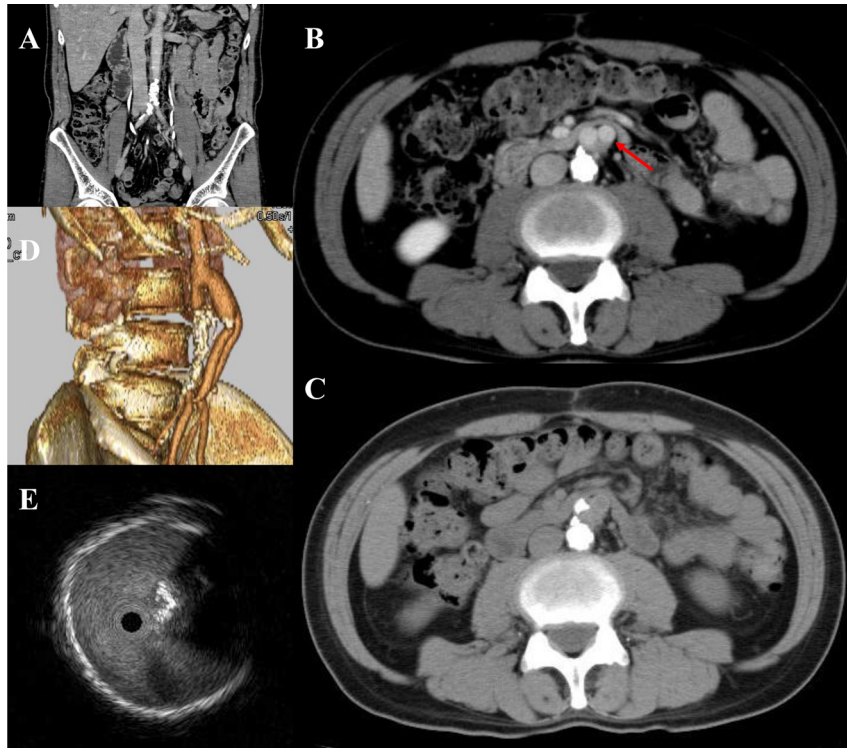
(A) A coronal view of preoperative computed tomography shows severe calcified stenosis of the distal abdominal aorta. (B) Computed tomography (1 year after the initial operation) shows no evidence of calcification in the implanted vascular prosthesis (red arrow). (C) Computed tomography (1.5 years after the initial operation) shows localized calcified stenosis in the right leg of the vascular prosthesis. (D) Three-dimensional computed tomography shows that the calcified lesion is located far from the anastomosis site. (E) Intravascular ultrasound finding of the calcified site.
